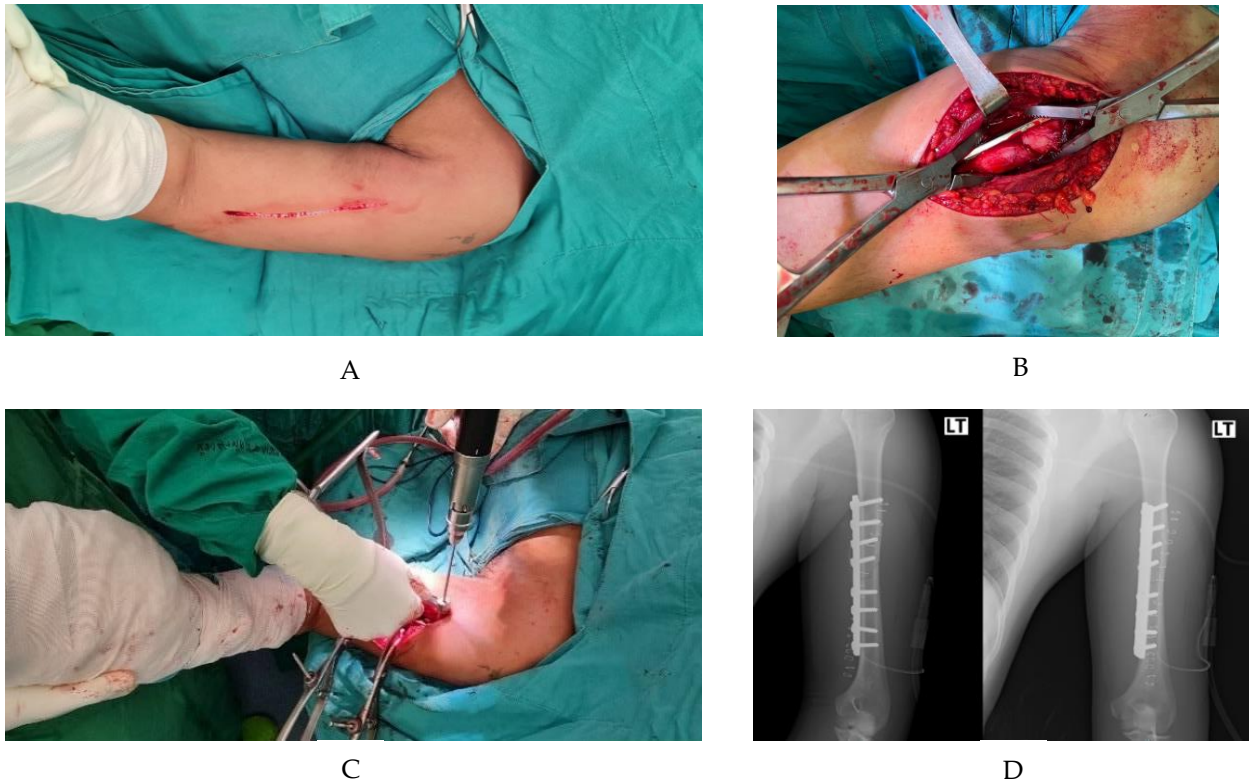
A: Skin incision. B: Exposure of the anteromedial surface of the humerus and application of the plate to the bone. C: External rotation of the arm and cortical screw fixation performance. D: Postoperative radiograph.
